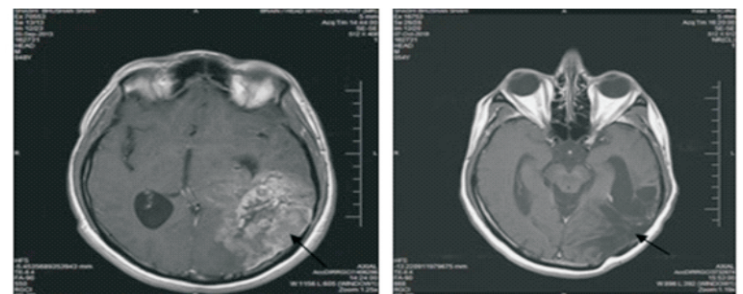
Left Temporo-occipital glioma pre-op MRI
